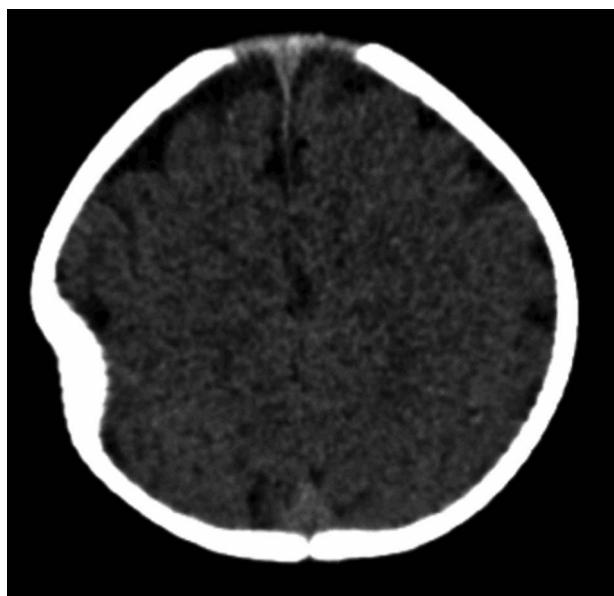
CT scan of infant's head demonstrating a concave depression of the right parietal bone.
